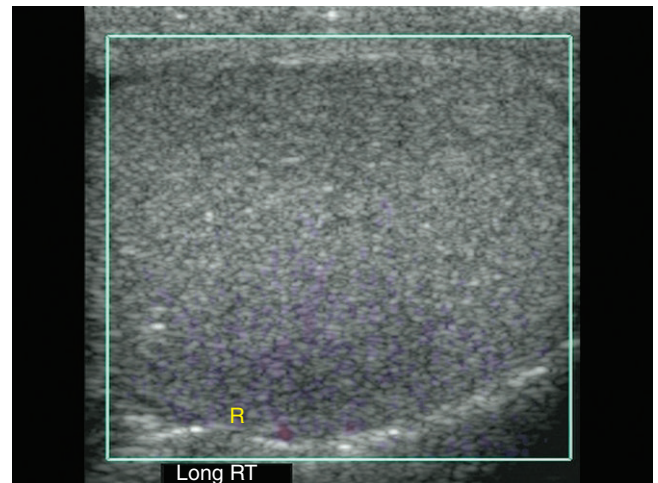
Color Doppler ultrasound of the right (R) testis showing absent color flow.
